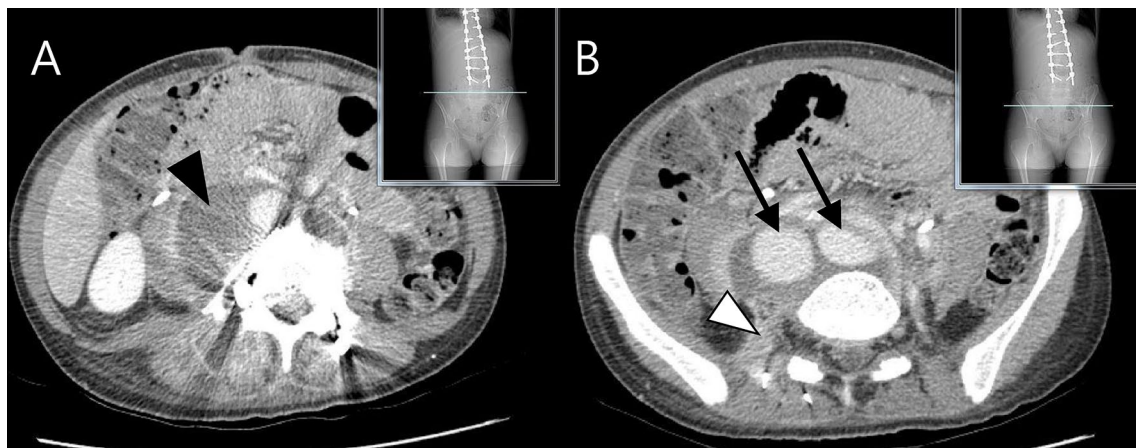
Abdomino-pelvic computed tomography (AP-CT) revealed a collection of pre- and paravertebral fluid collection (black arrowhead) surrounding a rim-like enhancement around the L3–5 level, containing more than two lobulated spaces filled with high-density-contrast
